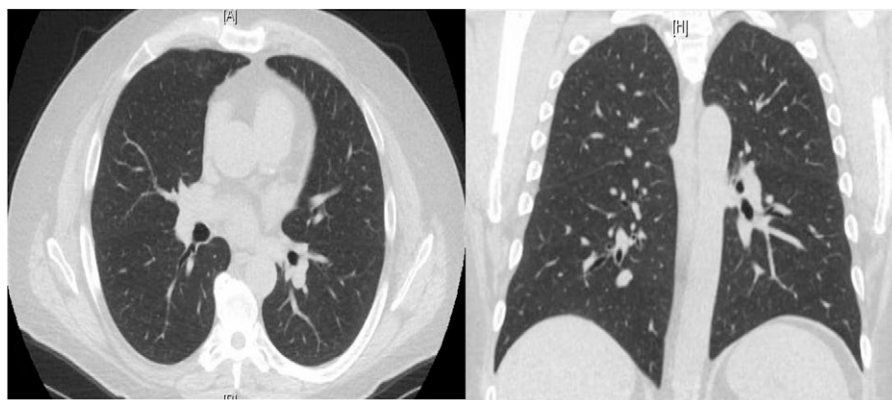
Repeated computed tomographic chest scan 2 weeks after the initial one, showing complete resolution of the airspace opacities.
